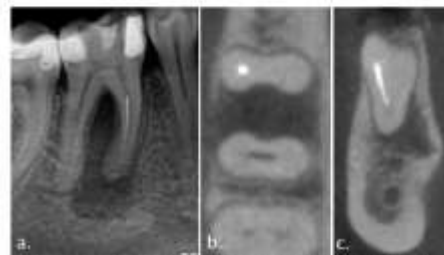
Preoperative condition a. Periapical radiograph b. Horizontal CBCT slice c. Frontal CBCT slice
